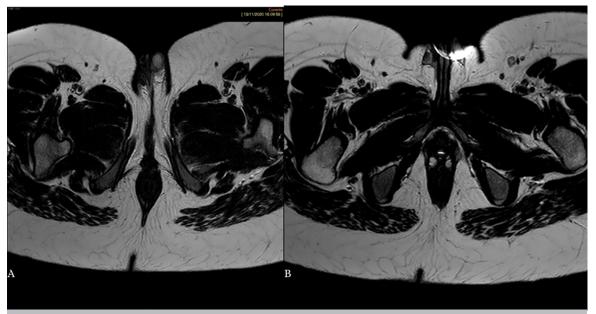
T2-weighted axial image: left (A) and right (B) testicles. Bilateral labioscrotal fold with hyperintense, asymmetrical and small testicles (left testis larger than right).
